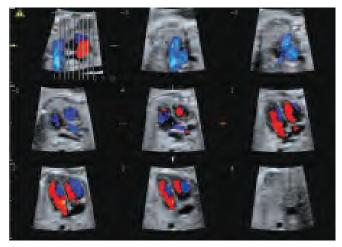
Tomographic ultrasound imaging (TUI) in a normal fetal heart at 20 weeks of gestation. TUI allows the diagnosis in one unique screen of multiples images
